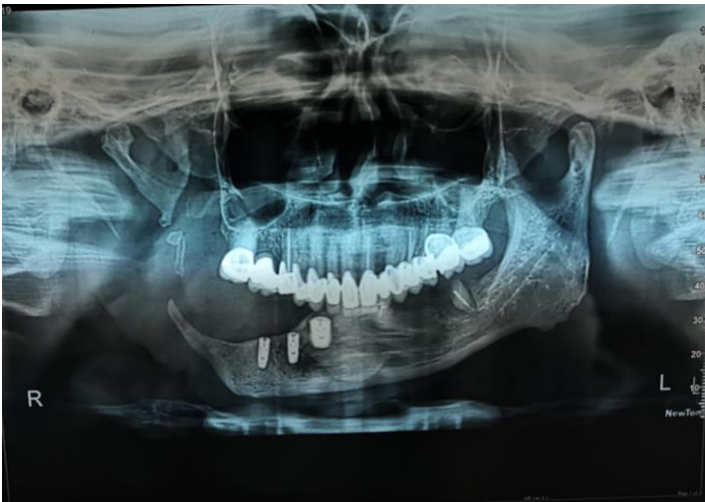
RADIOGRAPHIC VIEW POST IMPLANT PLACEMENT
